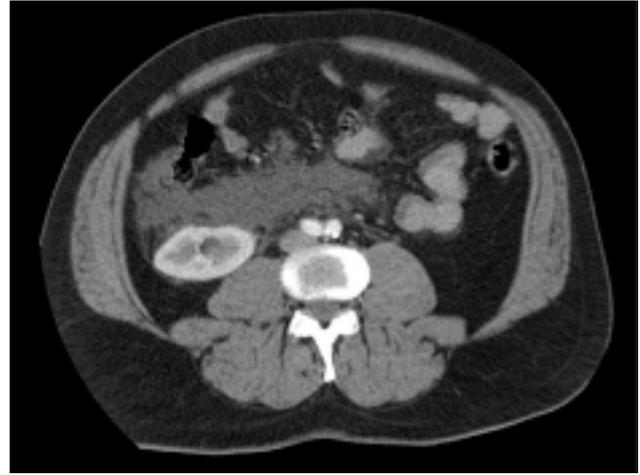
CT view of Urinoma
